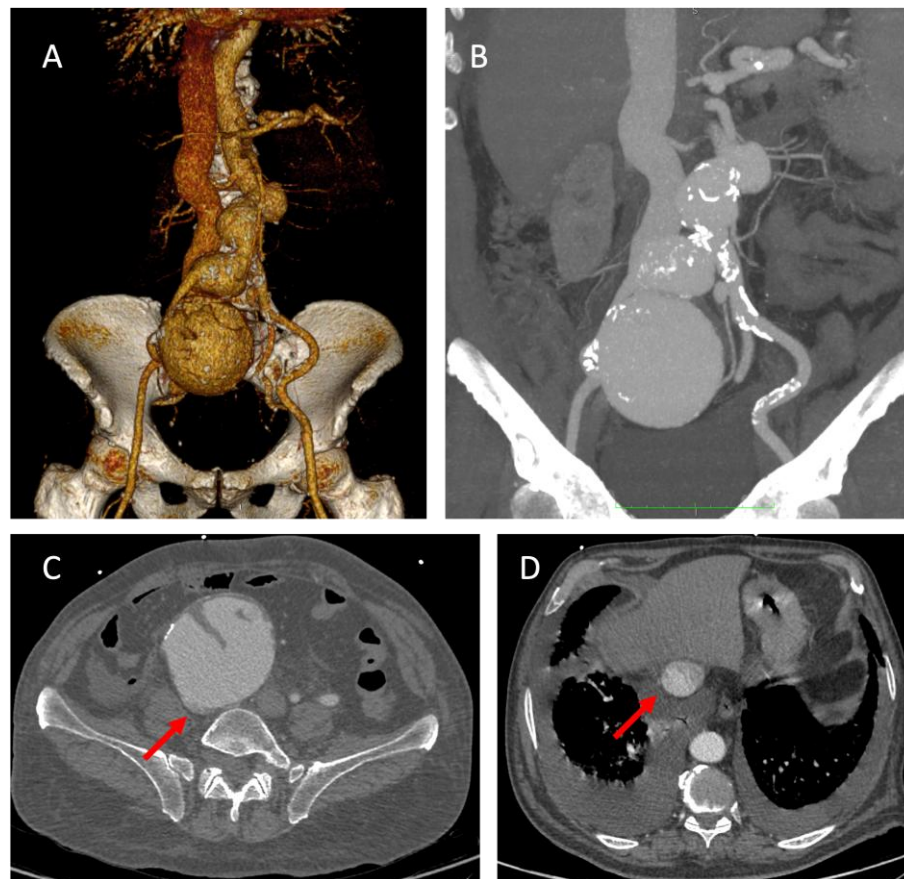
CTA documented infrarenal AAA, a right common iliac artery aneurysm, and a right external iliac artery aneurysm involving the origin of the internal iliac artery (A - B). The right iliac artery aneurysm presses the ipsilateral iliac vein (C). Same contrast opacification of the inferior vena cava with pleural effusion confirmed AVF with heart failure (D).
